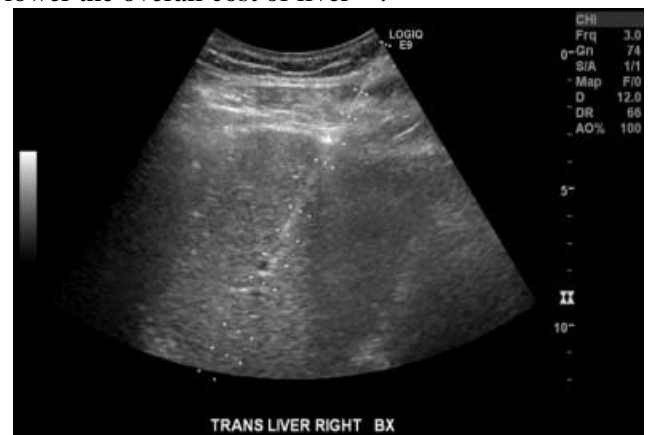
In the examination of a patient with known hepatitis C through a subcostal route, an ultrasound image shows real-time percutaneous needle placement for a random liver biopsy⁽⁵⁾.
